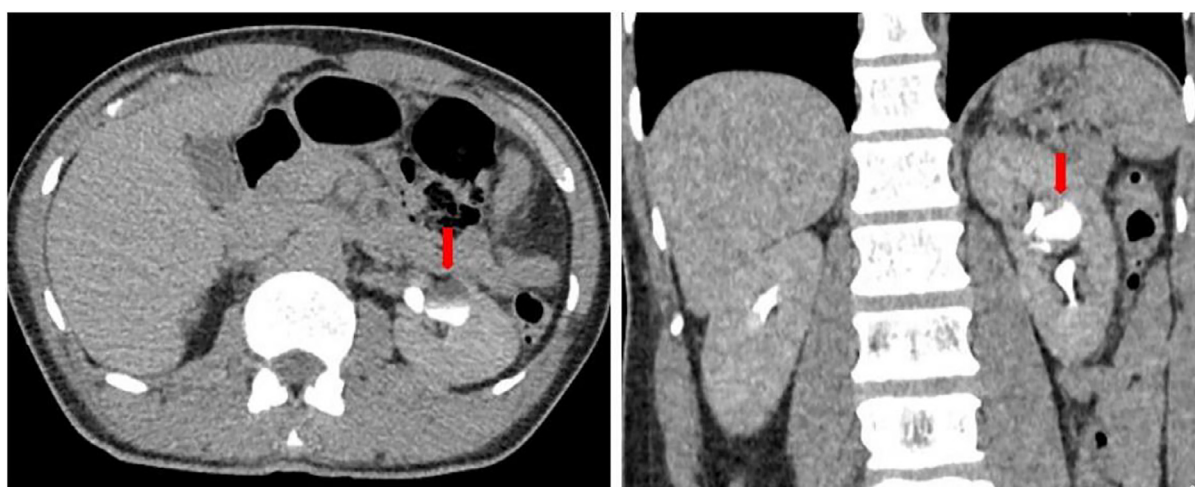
CT Urography (axial and coronal reformatted images) excretory phase showing excretion of contrast medium in the hypodense lesion in the mid-polar region of the left kidney which represents a focal dilatation of a mid-pole minor calyx (1.9 x 1.5) cm with subtle communication with the renal pelvis suggesting hydrocalyx (red arrows). The rest of the collecting system is unremarkable (Color version of the figure is available online.)
